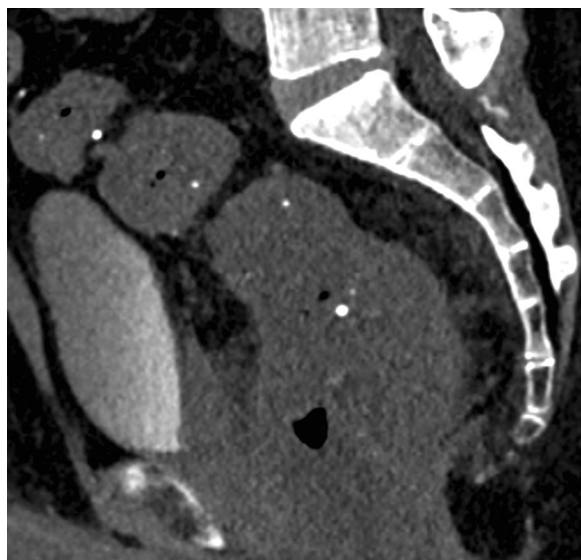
The non-contrast sagittal CT image shows multiple round foci of calcification consistent with phleboliths
